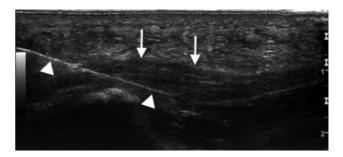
A 56-year-old man with inferior heel pain. Longitudinal sonogram of the plantar fascia demonstrates thickening (arrows) and hypoechogenicity. A 22G needle (arrowheads) is inserted from a proximal to distal approach inside the plantar fascia during plateletrich plasma treatment.
